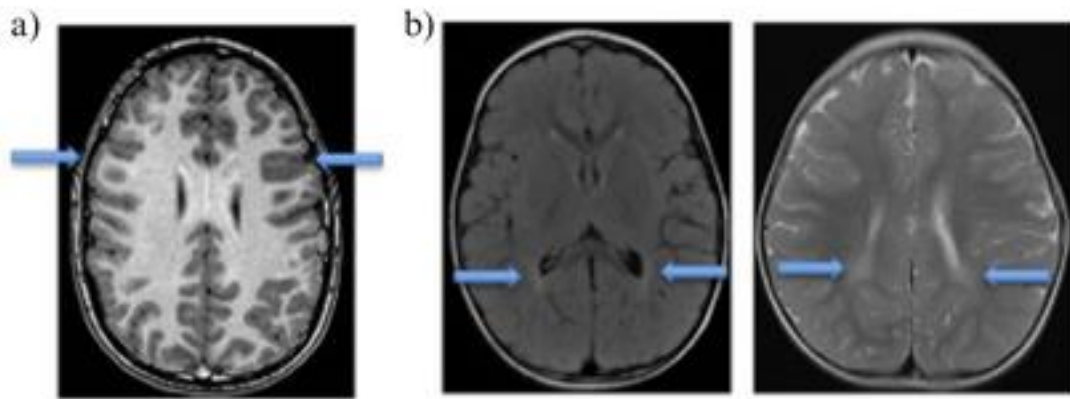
Brain MRI images (11)
